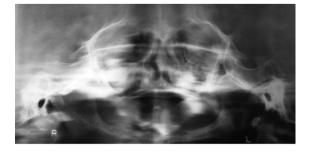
Orthopantomogram showing absence of all teeth or tooth buds.
